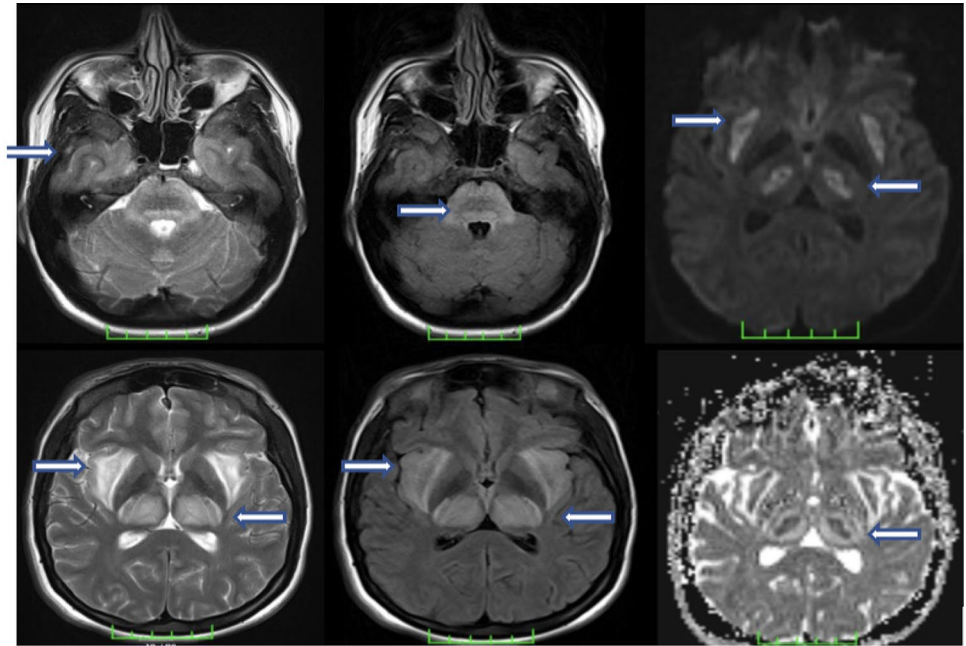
T2- and Flair-weighted images and diffusion MRI of the patient 6. There are extensive signal increases and diffusion restriction in the bilateral thalamus, external capsule, mesencephalon, pons, and mammillary body
